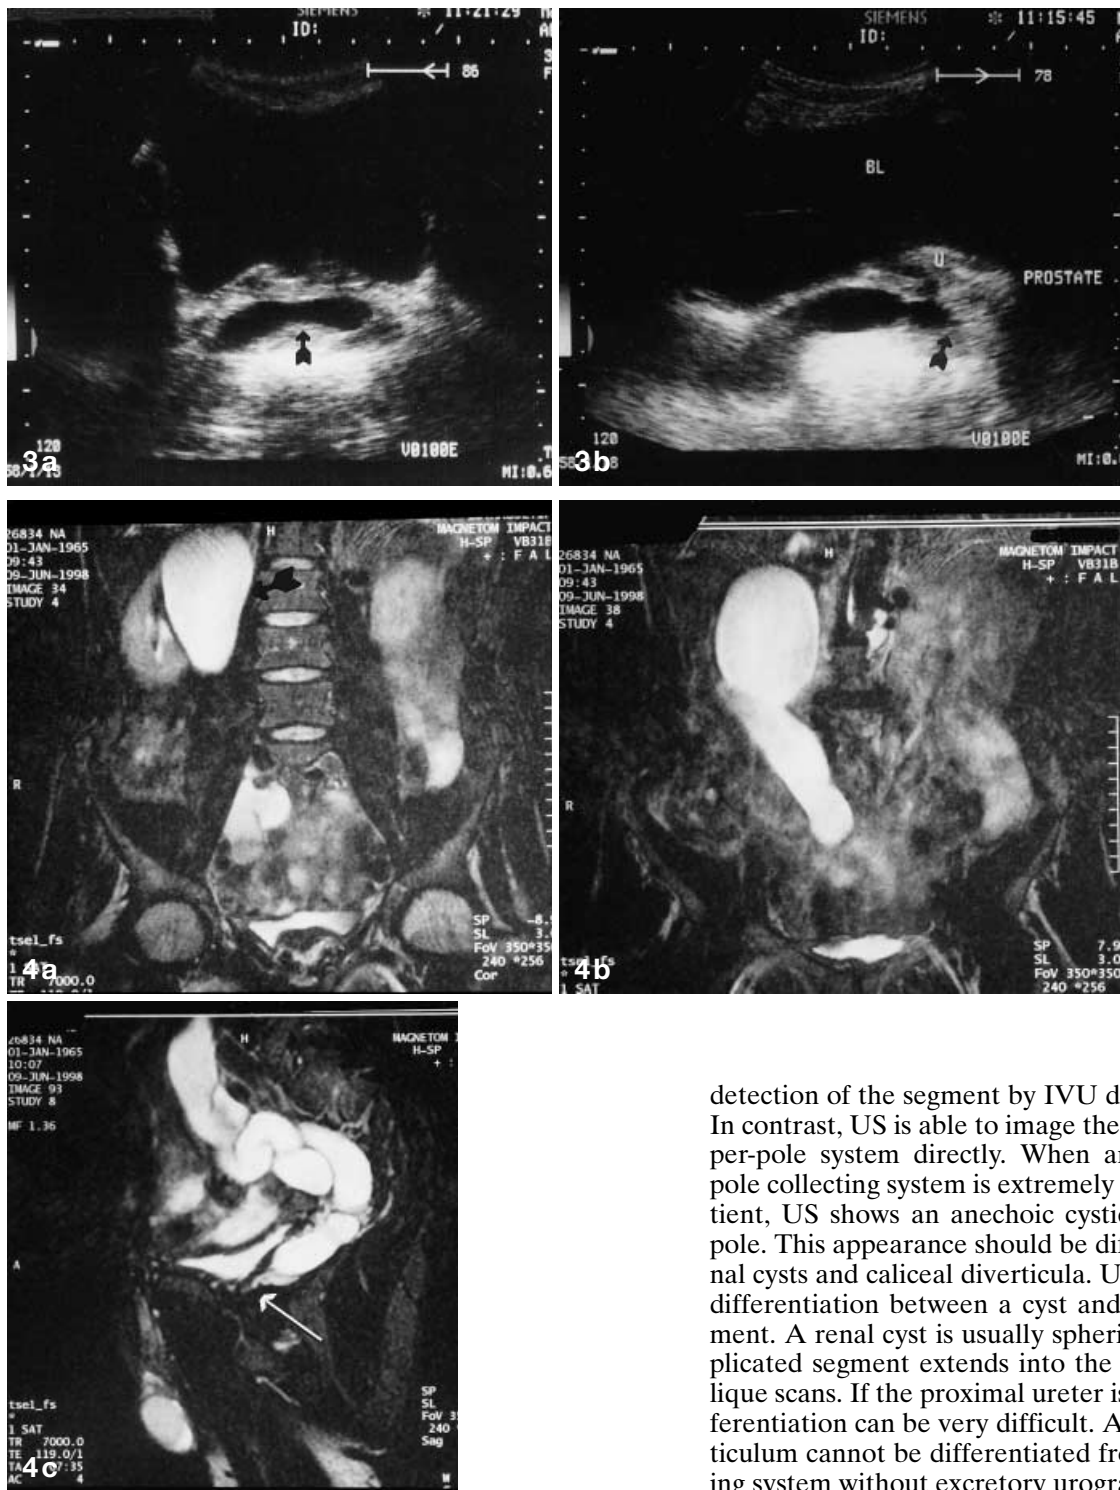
a Transverse transabdominal sonogram shows the dilated, extravesical ectopic ureter (*arrow*). b Sagittal transabdominal sonogram demonstrates insertion of the ectopic ureter into the prostatic urethra at the level of verumontanum (*arrow*)
